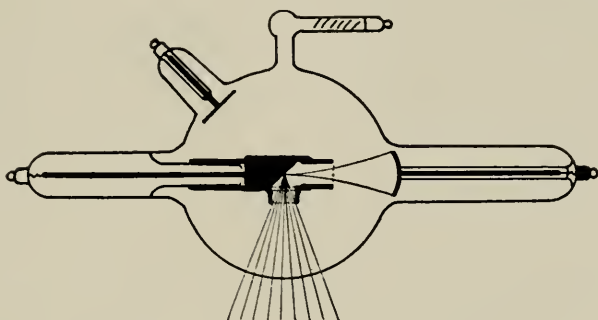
Protection or safety, X-ray tube.
